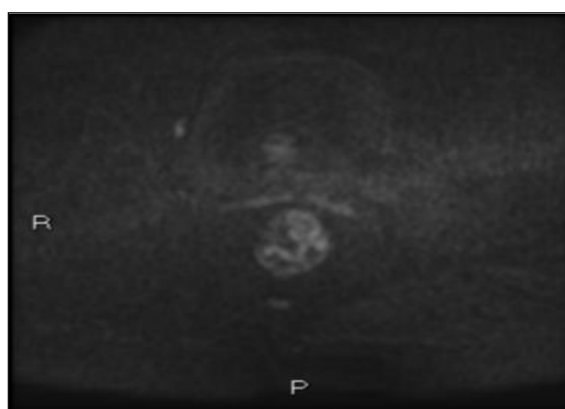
Location of tumor by DWI
